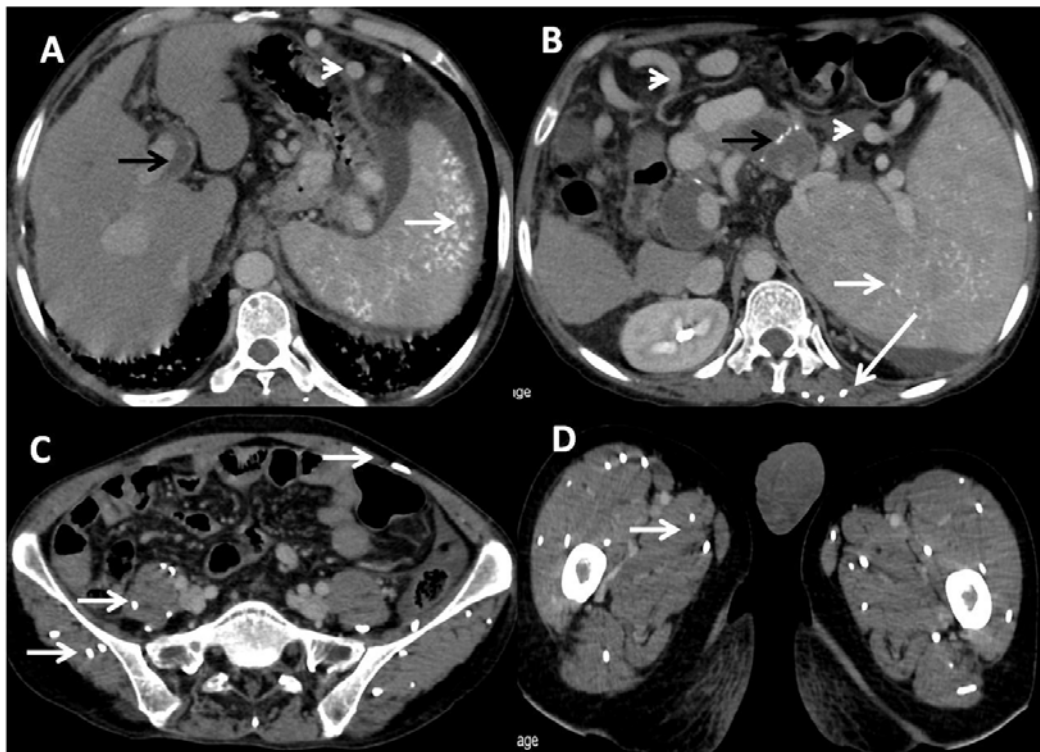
Contrast enhanced computed tomography (CECT) axial images show (Figure 1 A, B) shrunken liver with widened ligament falciparum fissure. The spleen is massively enlarged and shows multiple small specks of calcification (white arrows). The portal vein and splenic vein are distended with thrombus in which foci of calcification are evident (black arrows). Multiple collateral vessels are also seen (white arrow head). (Figure 1 C, D) - Rice grain like calcifications are seen in bilateral psoas, gluteal muscles, paraspinal muscles and thigh muscles
